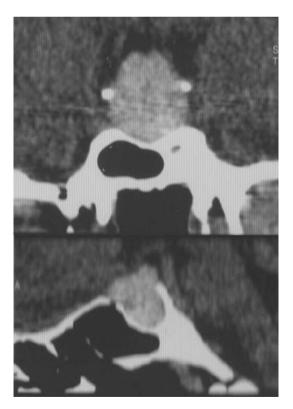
Coronal and sagital CT scans of the brain before the transphenoidal operation showing intrasellar and suprasellar mass lesion
